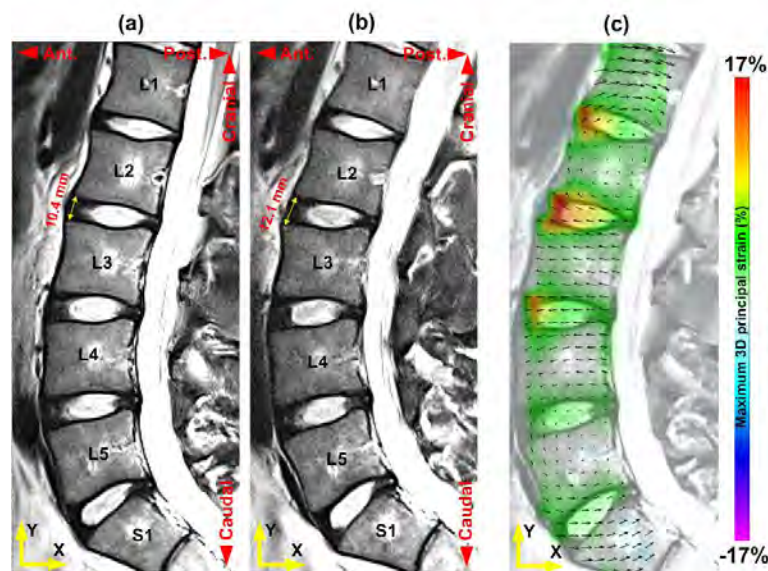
The mid-sagittal MRI slice of a lumbar spine in a neutral (a), and extended (b) posture. The maximum range of lumbar spine motion that could be achieved comfortably within the MRI scanner was obtained using a T2 TSE sequence. The depicted images are from a 27-year-old male subject. The MRI slice, with superimposed maximum 3D principal strains during extension is shown in (c). Black vectors identify the total 3D displacement of different locations within the lumbar spine during neutral to extension movement.
